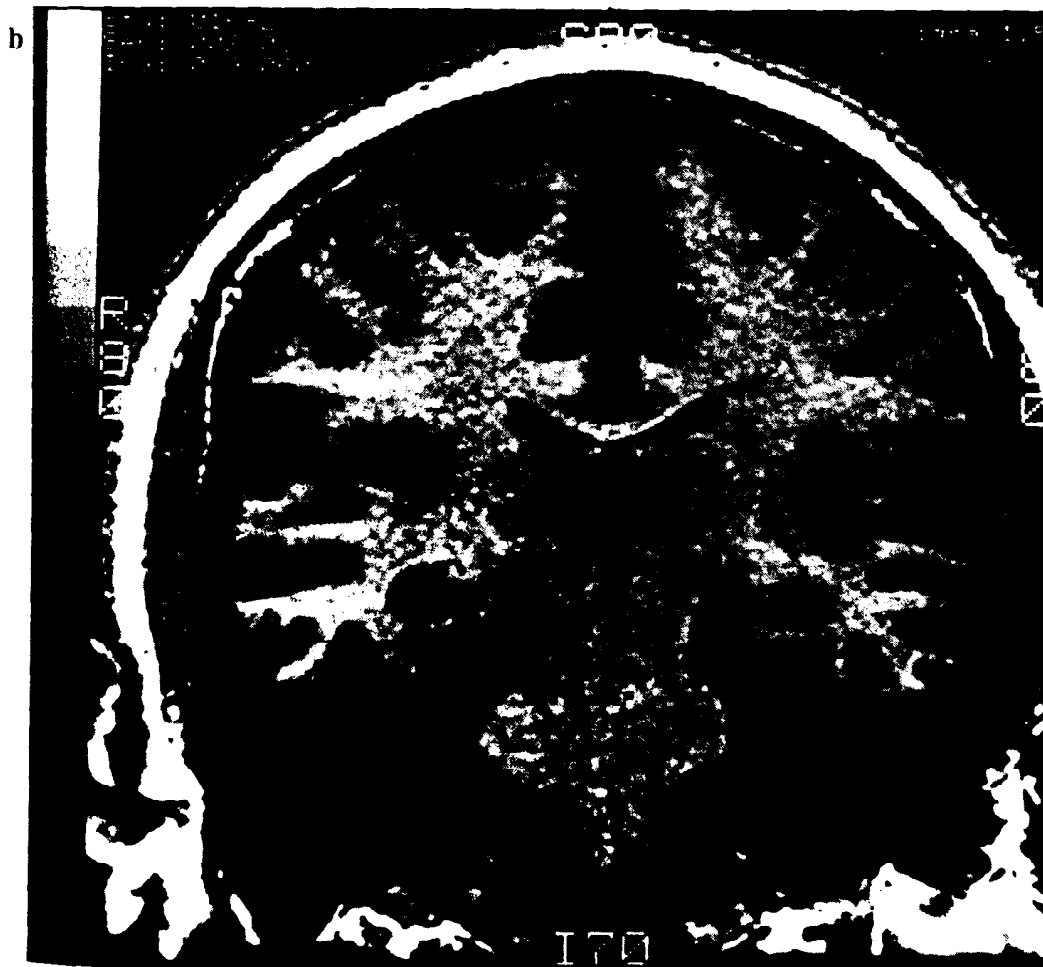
Coronal magnetic resonance imaging (MRI) scan in a patient with posttraumatic stress disorder (PTSD) (*a*) and a normal control (*b*). The hippocampus is visually smaller in the PTSD patient compared to the control.
